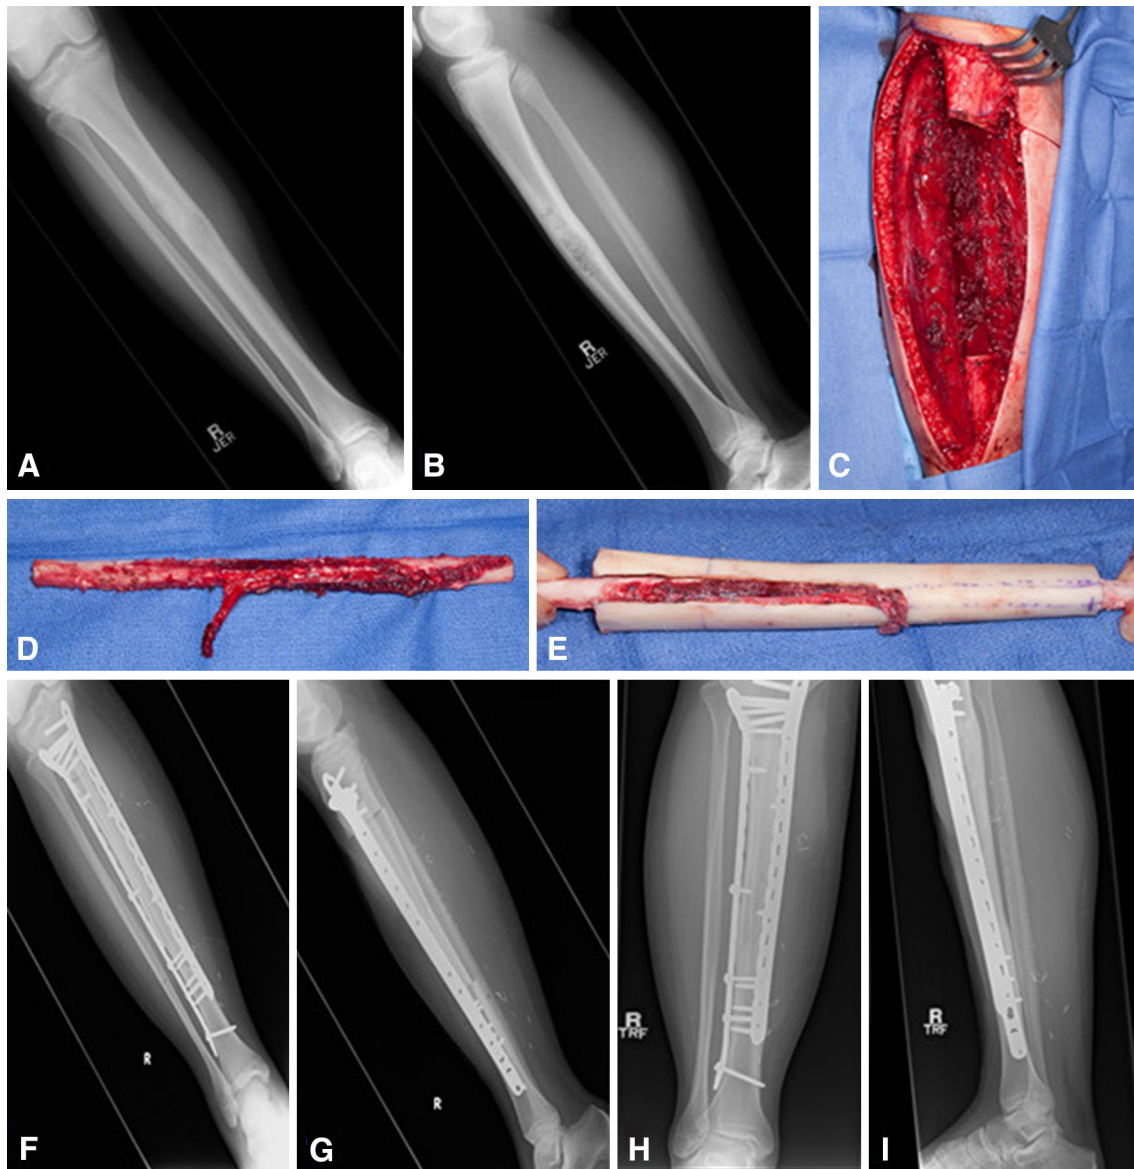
I Preoperative radiographs show a teenage patient with a tibial adamantinoma (A–B). The decision was made to treat the patient using the Capanna technique with an intraoperative photograph of the postresection defect (C). The bony defect was filled by
